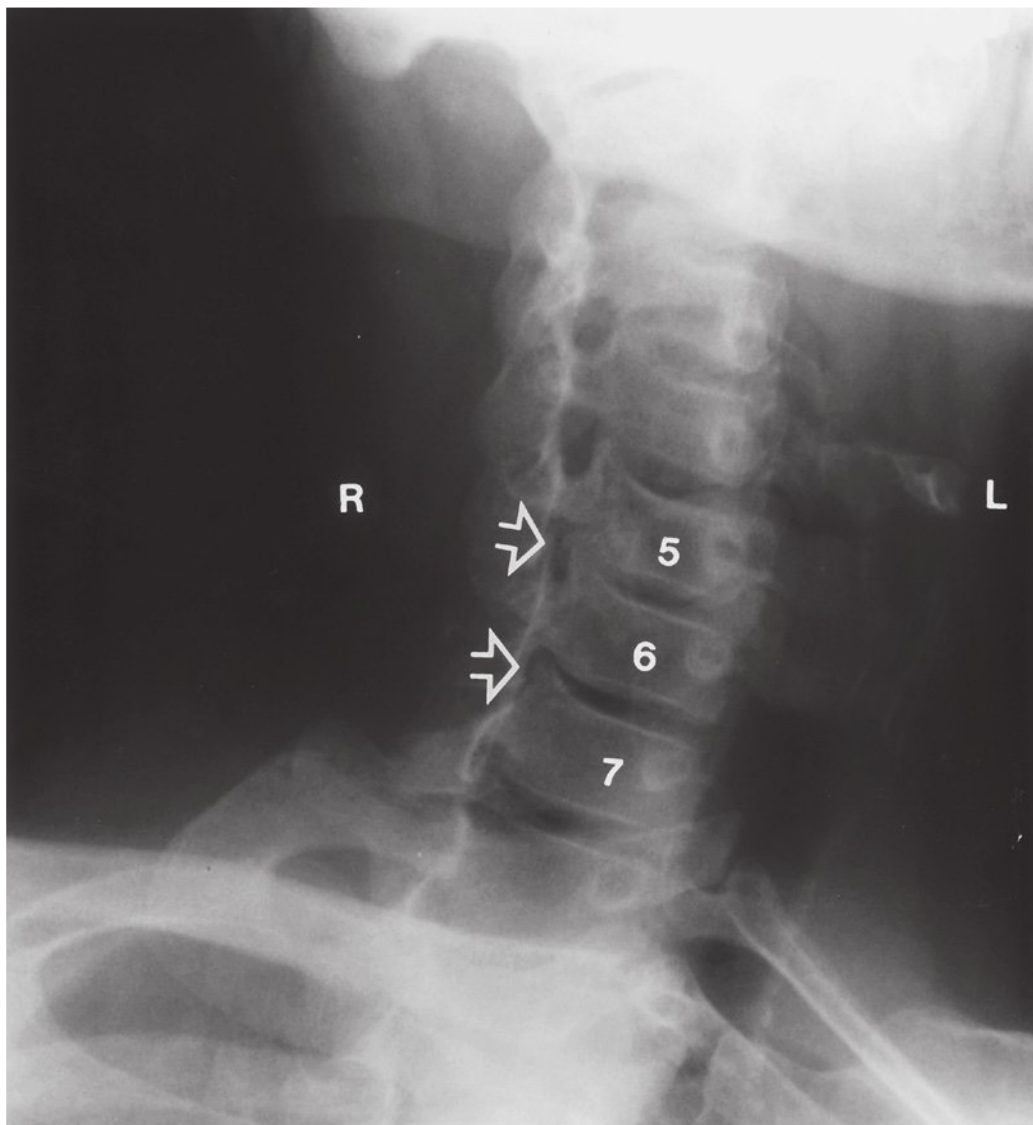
An oblique cervical spine radiograph demonstrating neuroforaminal stenosis secondary to osteophyte formation at the uncinates.
